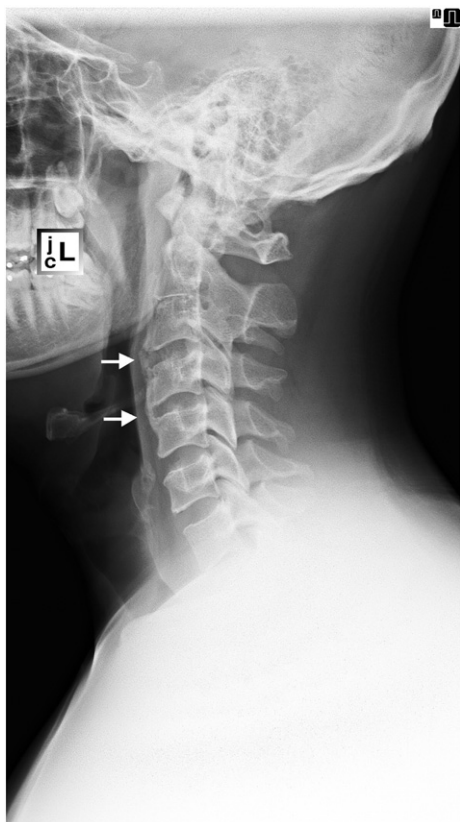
This lateral cervical radiograph was taken 16 months after the accident. Note that the ALL is ossified from C3 through C5. This is an atypical presentation of HO.
